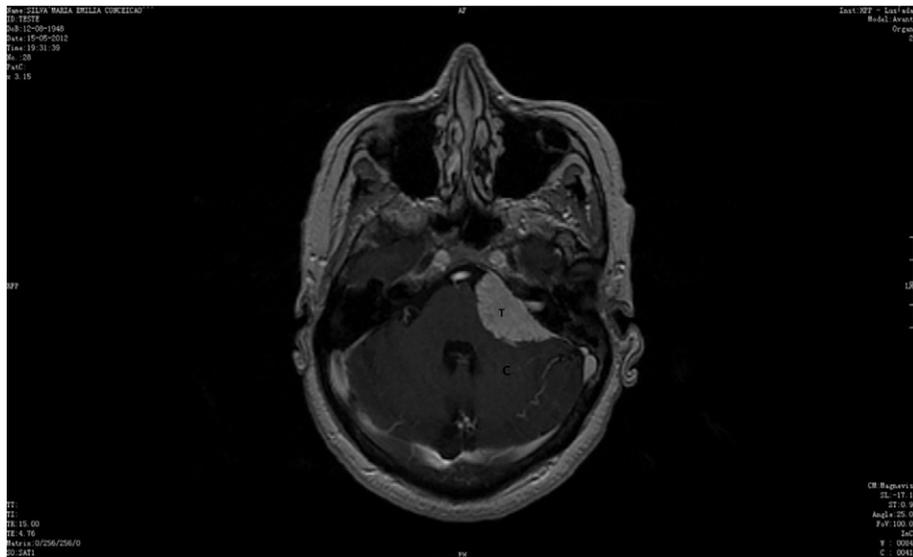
Axial T1-weighted MR image with gadolinium contrast enhancement showing left-sided extra axial tumor, centered to the internal auditory canal (possible meningioma). T: Tumor, C: Cerebellum.
